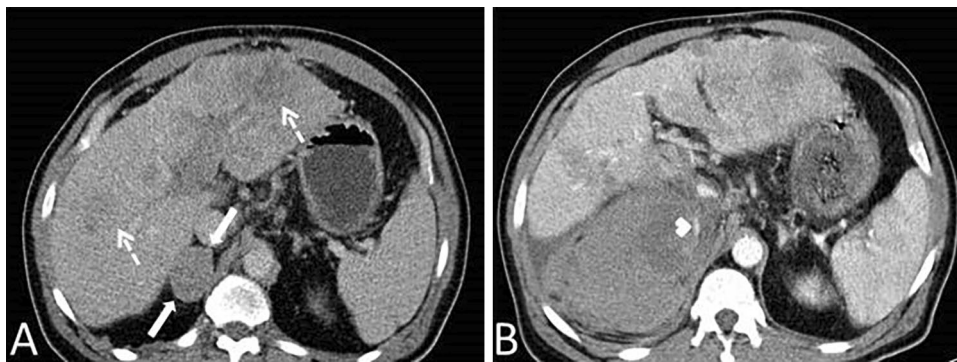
58-year-old male patient with known HCC. A Axial postcontrast CT image shows liver masses (dashed arrows) and right adrenal mass (arrows). The patient presented with severe, acute right upper quadrant pain 15 days after this CT scan. B Axial postcontrast CT
